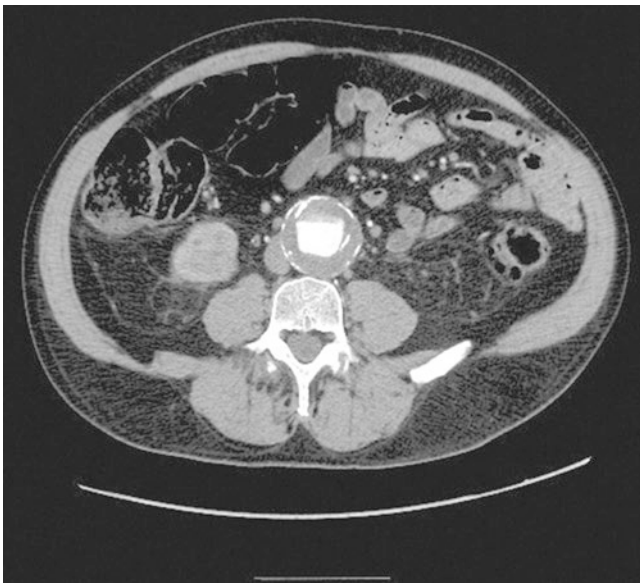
CTA of abdomen/pelvis demonstrating AAA. Note the calcified rim of the aorta which is one of the short comings of CT imaging. Calcium artifacts are common (axial imaging)
